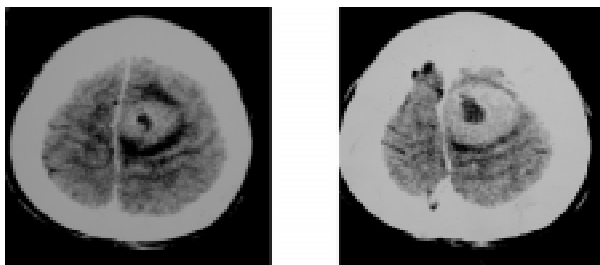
CT scan of brain showing a thick walled enhancing lesion with central necrosis and peri-lesional edema seen in left high para-sagittal region
